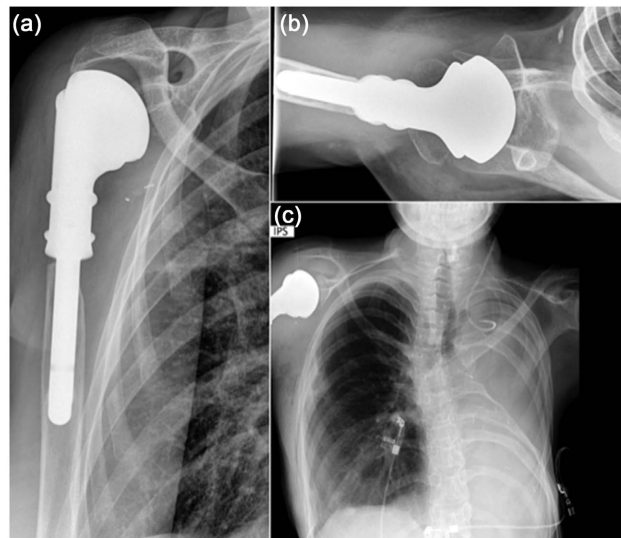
X-Rays at 8 years follow-up documenting the stable well centered reconstruct (a, b). Thorax X-Ray after pneumonectomy (c) following earlier complications of metastasectomy.
